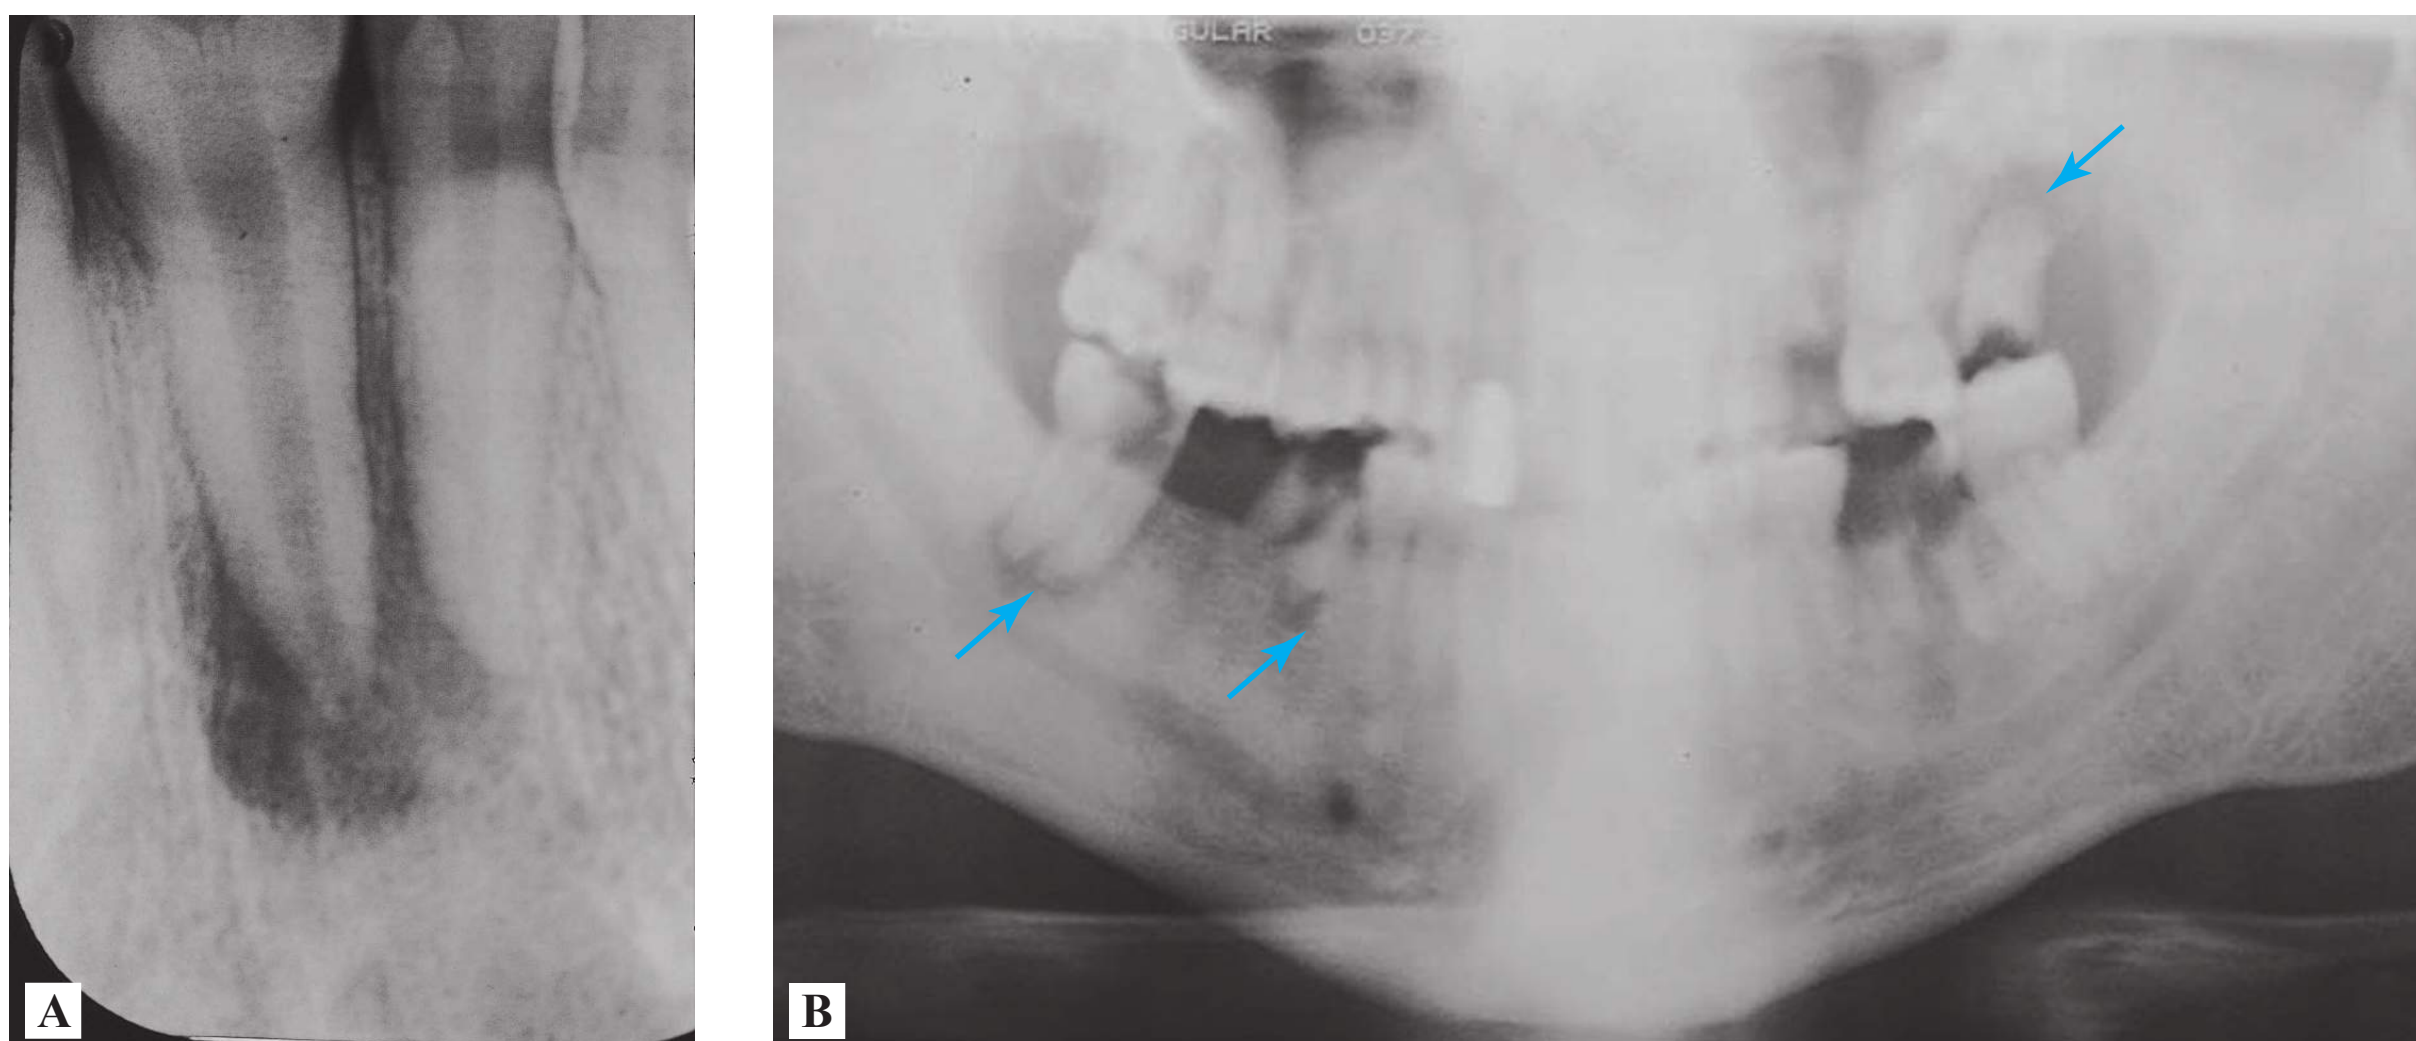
■ Periapical Abscess. (A) Note the well-defined radiolucent area at the apex and lateral root of the tooth in this radiograph. (Photo contributor: James L. Kretzschmar, DDS, MBS.) (B) This Panorex film shows lucencies consistent with periapical abscesses, most notably of the right inferior posterior molar tooth (see arrows). (Photo contributor: David P. Kretzschmar, DDS, MS.)
